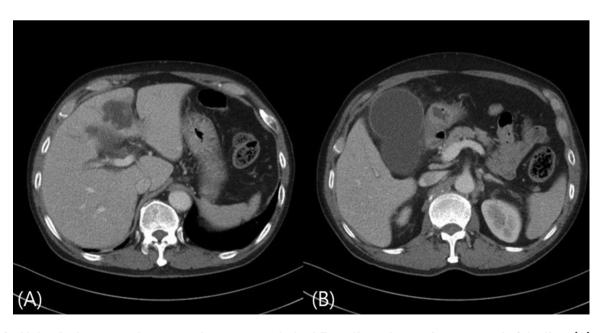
Abdominal computed tomography scan revealed a 4.5-cm liver abscess in segment 4 of the liver (A) and a dilatated gallbladder with diffuse inflammatory thickening (B).
